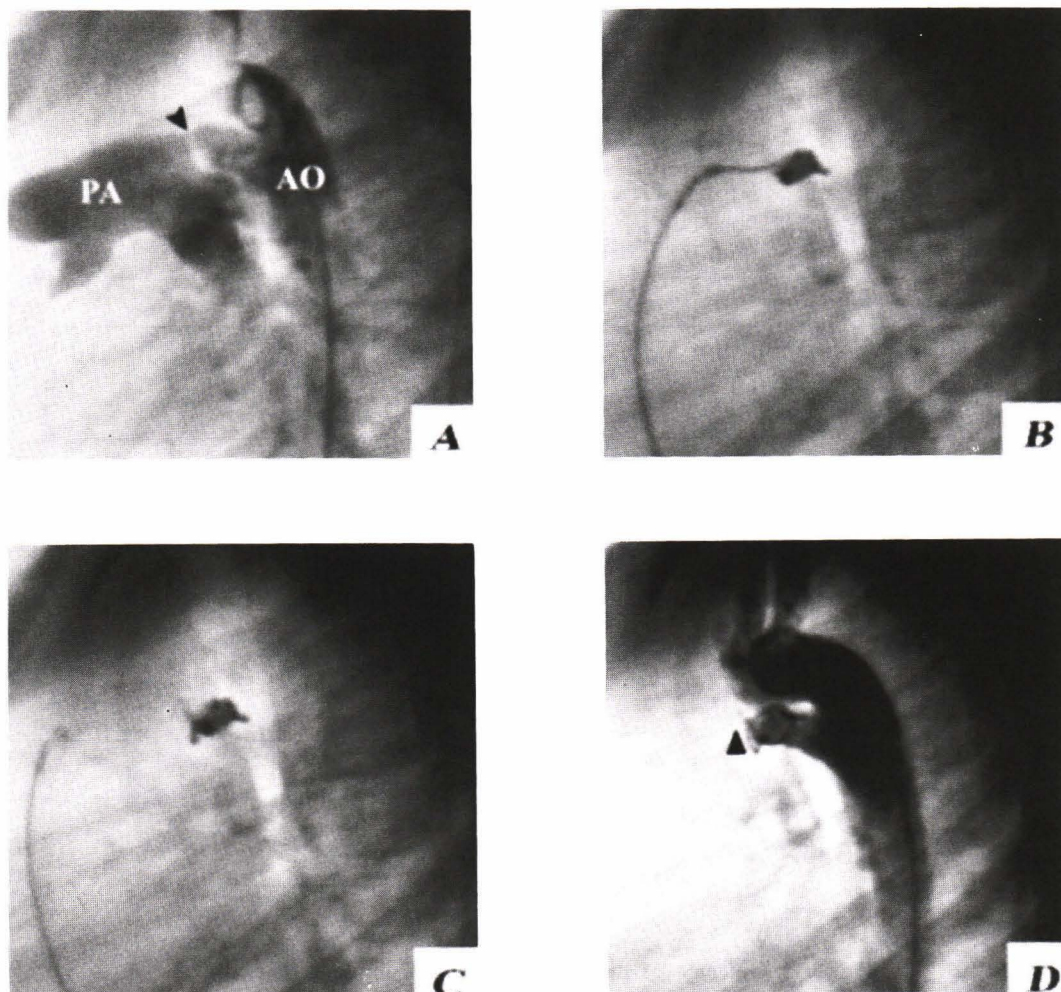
Coil occlusion of PDA using 0.052 inch Gianturco coil. A, lateral aortography in a 5 year old boy showed elongated conical shape PDA with the narrowest diameter of 4 mm (arrow head). B, one 0.052 inch coil, 8 mm in diameter, formed tight loops in the aortic ampulla. The coil was still firmly grasped by the jaws of the biptome. C, after being satisfied with the coil's position and its stability, the jaws of the biptome were opened to release the coil. D, repeat aortography showed trivial residual PDA leakage as a Smokey appearance in the pulmonary end (arrow head). Echocardiograph, at the 3-month follow-up, showed complete occlusion of the PDA.
